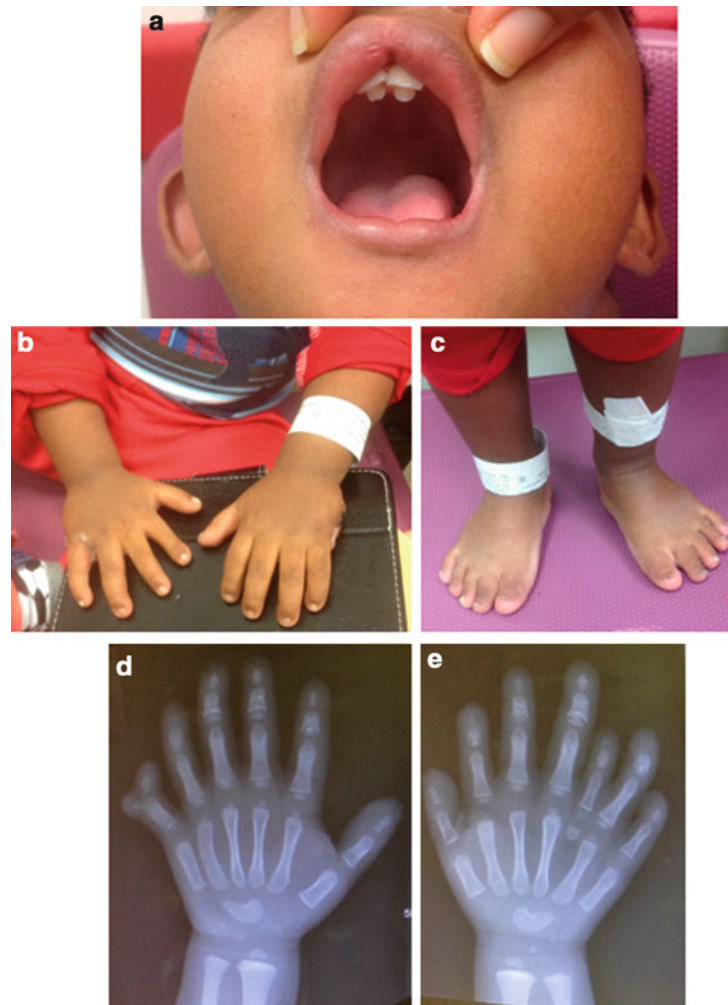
(a–e) This 3-year-old Hispanic boy from Panama was seen for abnormal dentition and brachydactyly and polydactyly of both hands. Orofacial features were characterized by slight hypertelorism, flat nasal bridge, and presence of median pseudocleft of the upper lip and double rows of upper central incisors with absence of other teeth (a). Radiographic imaging of oromandibular areas with panoramic and cephalometric projection showed no permanent maxillary laterals and complete absence of all central and lateral mandibular teeth (not shown). The fingers were short with postaxial polydactyly of both hands (seven fingers on the right and six fingers on the left with duplicated distal end of the last finger) (Status post incision of polydactylies and post reconstruction of both hands is shown here) (b). There was no polydactyly of the toes, but the great toes were slightly broad. Radiograph of left hand (d) showed duplication of the fifth ray with dysplasia and hypoplasia of the distal and middle phalanges. Radiograph of the right hand (e) showed duplication of the fourth and fifth rays with dysplasia and hypoplasia of the distal and middle phalanges. Dysplastic fusion of the capitate and hamate was present in both wrists (d, e)
